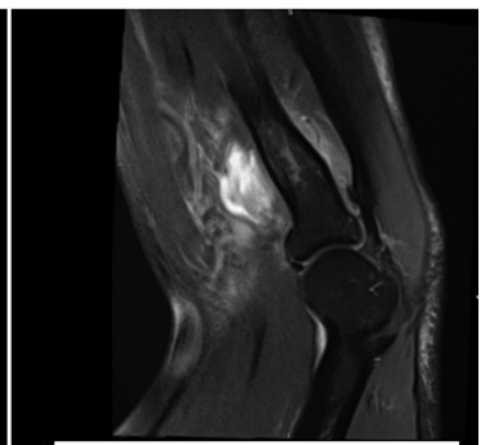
MRI Elbow Incomplete tear L biceps tendon
